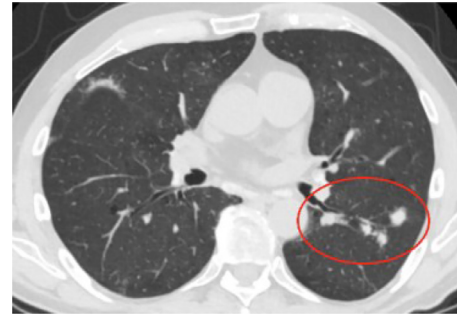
Chest CT with contrast, lung window, showing hyperdense nodular opacities in left lower lobe circled in red.
